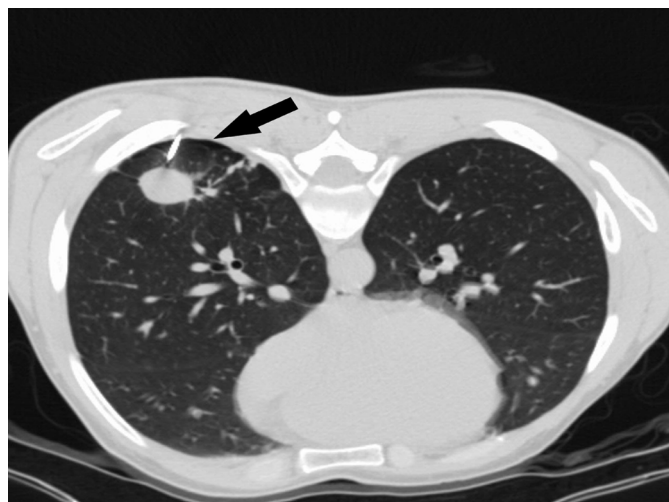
Axial CT scan, Pneumothorax occurring during the procedure is observed. (black arrow)
